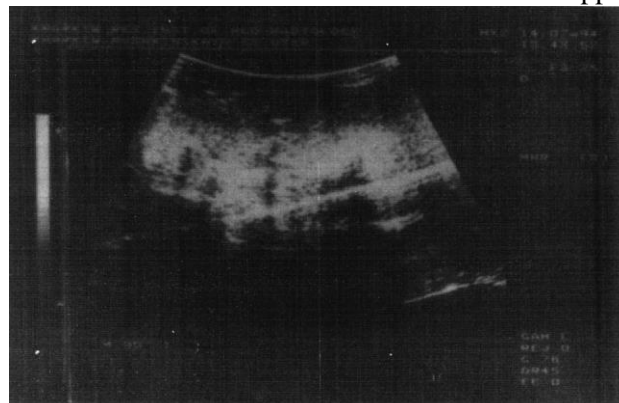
Ultrasound scan of the liver on the right meridian
